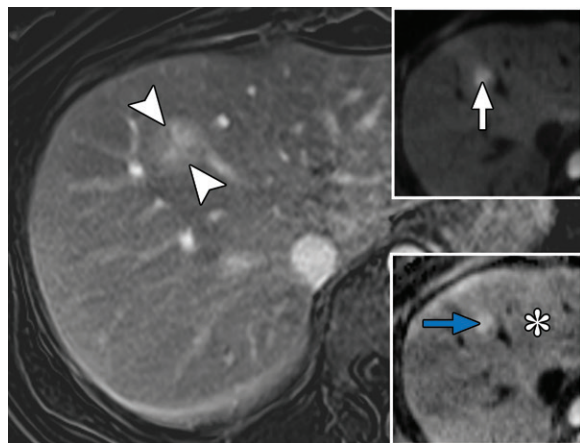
Interpretation of T2 shine-through at DWI in a 27-year-old woman with Li-Fraumeni syndrome who underwent MRI to evaluate a liver lesion depicted at whole-body screening MRI. Axial T1-weighted arterial phase subtraction MR image shows an enhancing liver mass (arrowheads) at the junction of segments VIII and IVa. The lesion is hyperintense to background liver on both the diffusion-weighted image (top inset, white arrow) and ADC map (bottom inset, blue arrow), which might be interpreted as T2 shine-through and fast diffusion. However, the liver is not always a useful comparator, as the background liver, in this case, is relatively hypointense (*) on the ADC map. Quantitatively, the ADC of the lesion is $1.3 \text{ mm}^2/\text{sec}$, compared with $2.5 \text{ mm}^2/\text{sec}$ of the cerebrospinal fluid, indicating some degree of diffusion restriction. The results of a subsequent biopsy confirmed hepatic adenoma.
